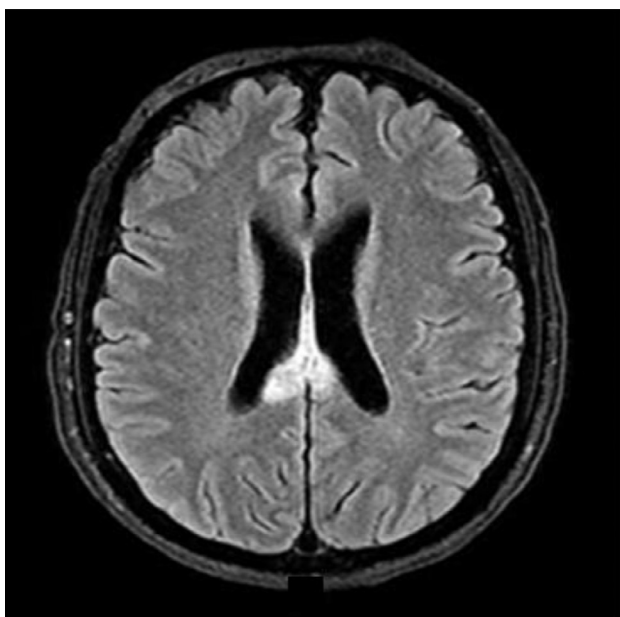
Axial FLAIR image shows abnormal high signal intensity in the splenium of the corpus callosum (left) which exhibits restricted water diffusion on the DWI (right).
